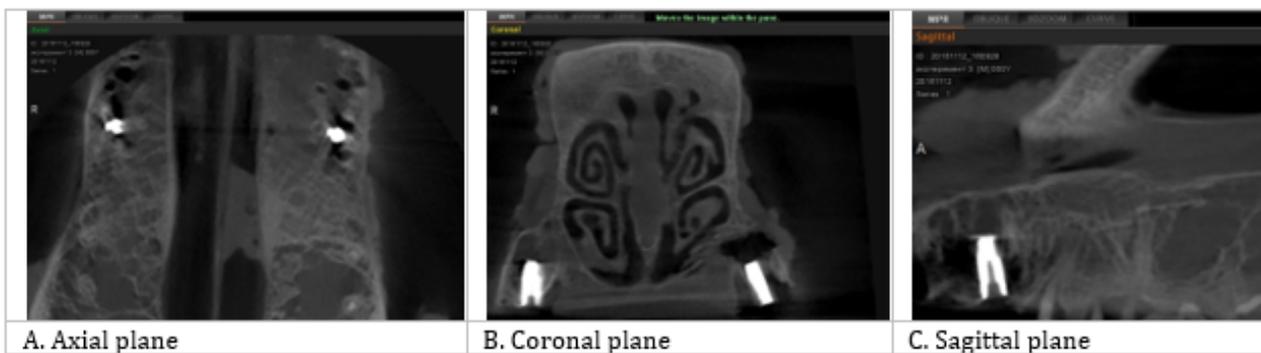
Control CBCT after direct dental implantation in the inter-root septum in the experiment.
